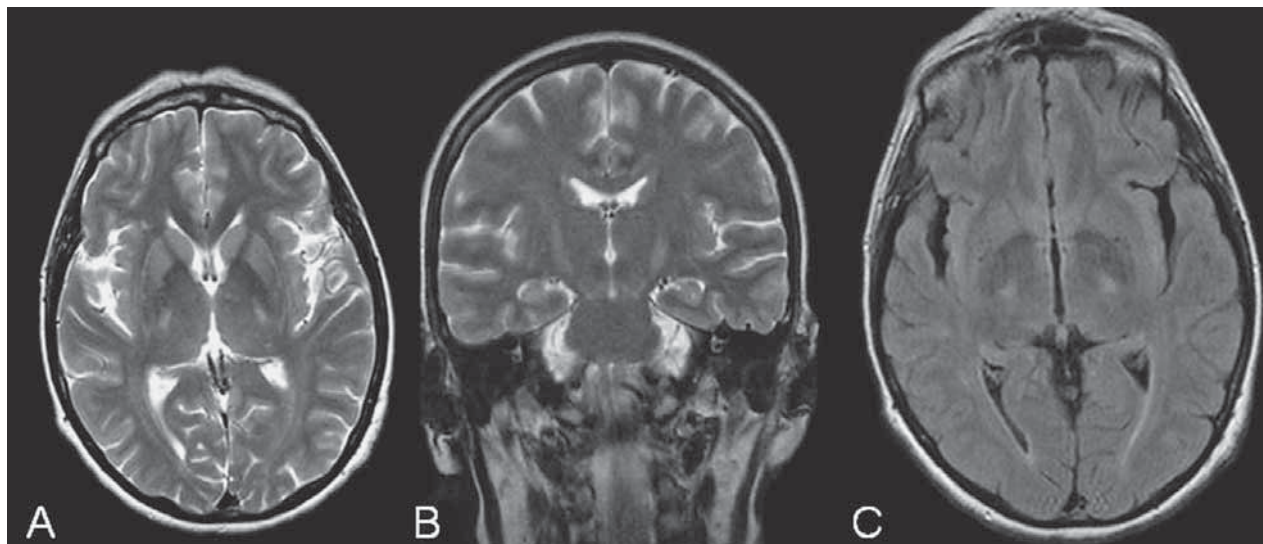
(A, C). Axial T2 and FLAIR weighted MR images showing bilateral hyperintensities in posterior limb of the internal capsule; (B) coronal T2-weighted MR image showing ‘wine-glass’ sign with symmetrical corticospinal tract hyperintensities reaching the pontine level.
